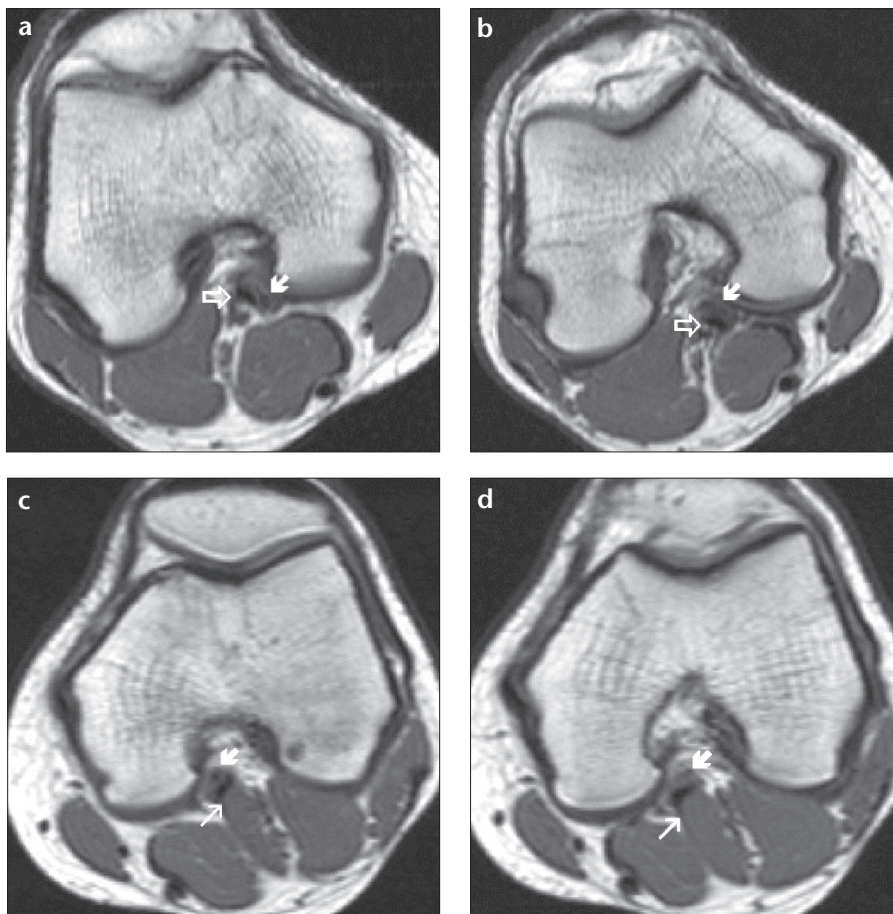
a-d. Transverse T1 weighted sequential MR images of the right knee (a and b) show the popliteal artery entrapped by an aberrantly coursed tendon (*open arrow*) originating from the medial head of gastrocnemius muscle (*white arrow*). Transverse T1 weighted sequential MR images of the left knee (c and d) show popliteal artery (*thick arrow*) entrapped by the laterally originated medial head of the gastrocnemius muscle (*thin arrow*).
